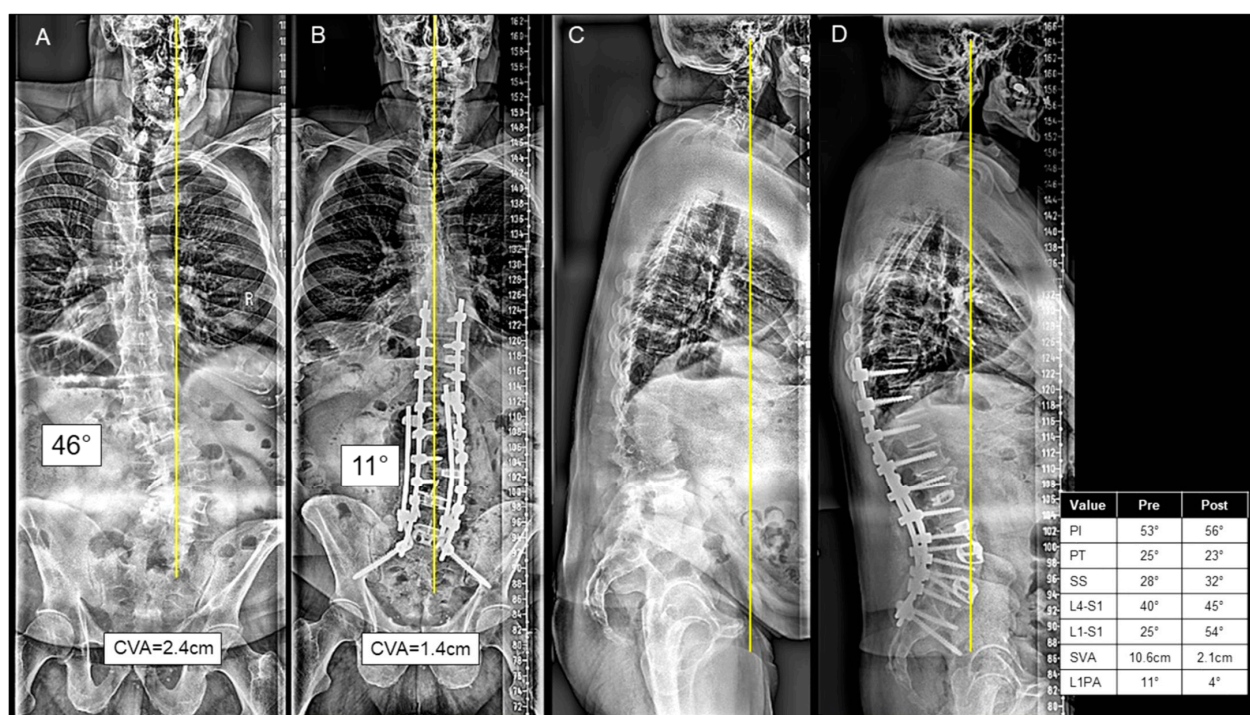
(A–D) A case presentation of a 67-year-old male presenting with L3–L4 left-sided radiculopathy and sagittal malalignment due to lumbar kyphosis causing severe mechanical back pain on the postero-anterior (PA) (A) and lateral X-rays (C). The patient underwent a stage 1 anterior lumbar interbody fusion at L4–5 and L5–S1. Two days later, the patient underwent a posterior approach consisting of T10–ilium instrumentation, posterior column osteotomies from T12–L5, inferior facetectomies from T10–S1, and L2/L3 and L3/L4 transforaminal lumbar interbody fusion, as seen on the postoperative PA (B) and lateral X-rays (D). The patient was discharged to IPR at postoperative day 9.
